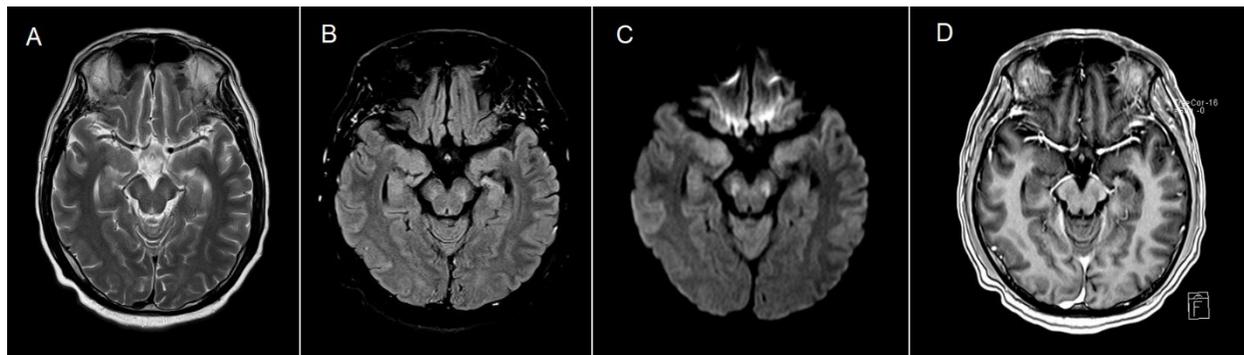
Magnetic resonance images of the patient.
